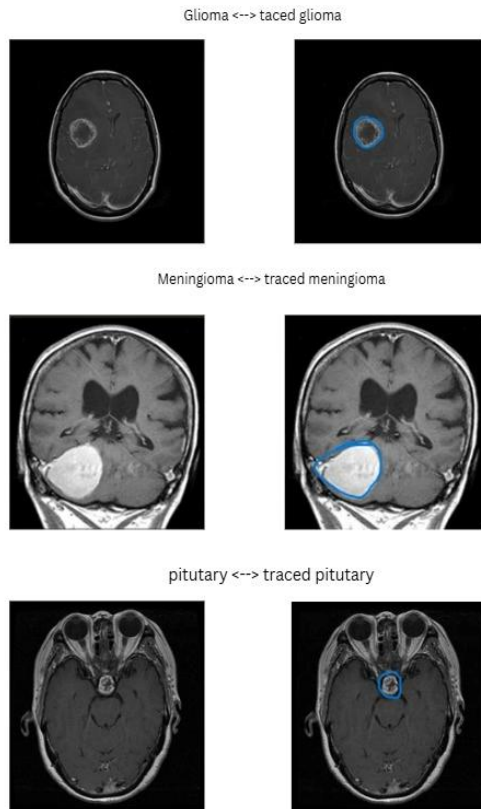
Classical mask validation: each row shows the original MRI (left) and the detected boundary (right). Blue ellipse = `cv2.fitEllipse` output. Top to bottom: glioma (area 1.5%), meningioma (19.6%), pituitary (0.6%), no-tumor (no boundary)
